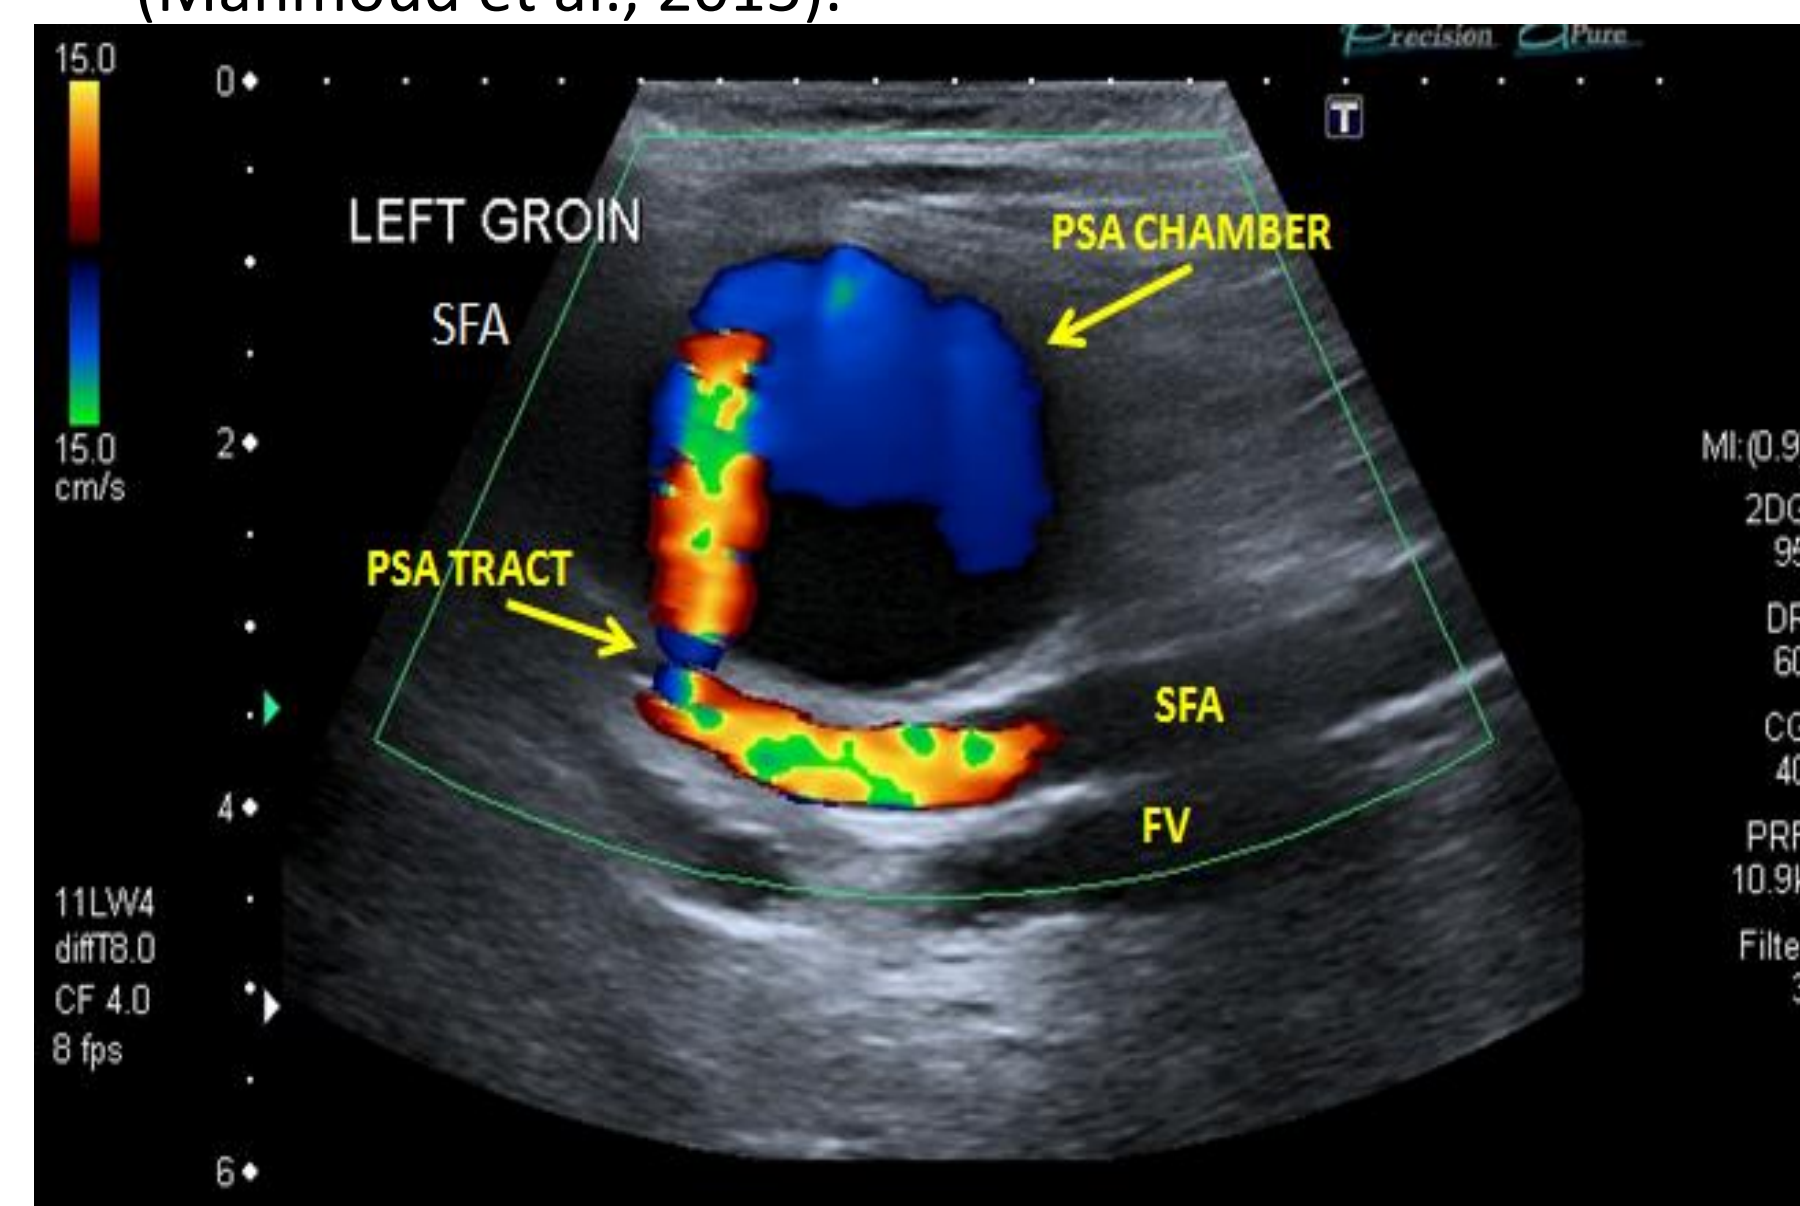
LS colour Doppler image reveals a tract (or neck) connecting the PSA chamber to the SFA. Blood flow is also visualised within the chamber.
